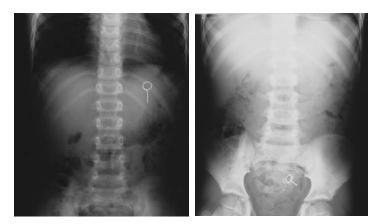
Radiograph showing the swallowed object in the stomach.
